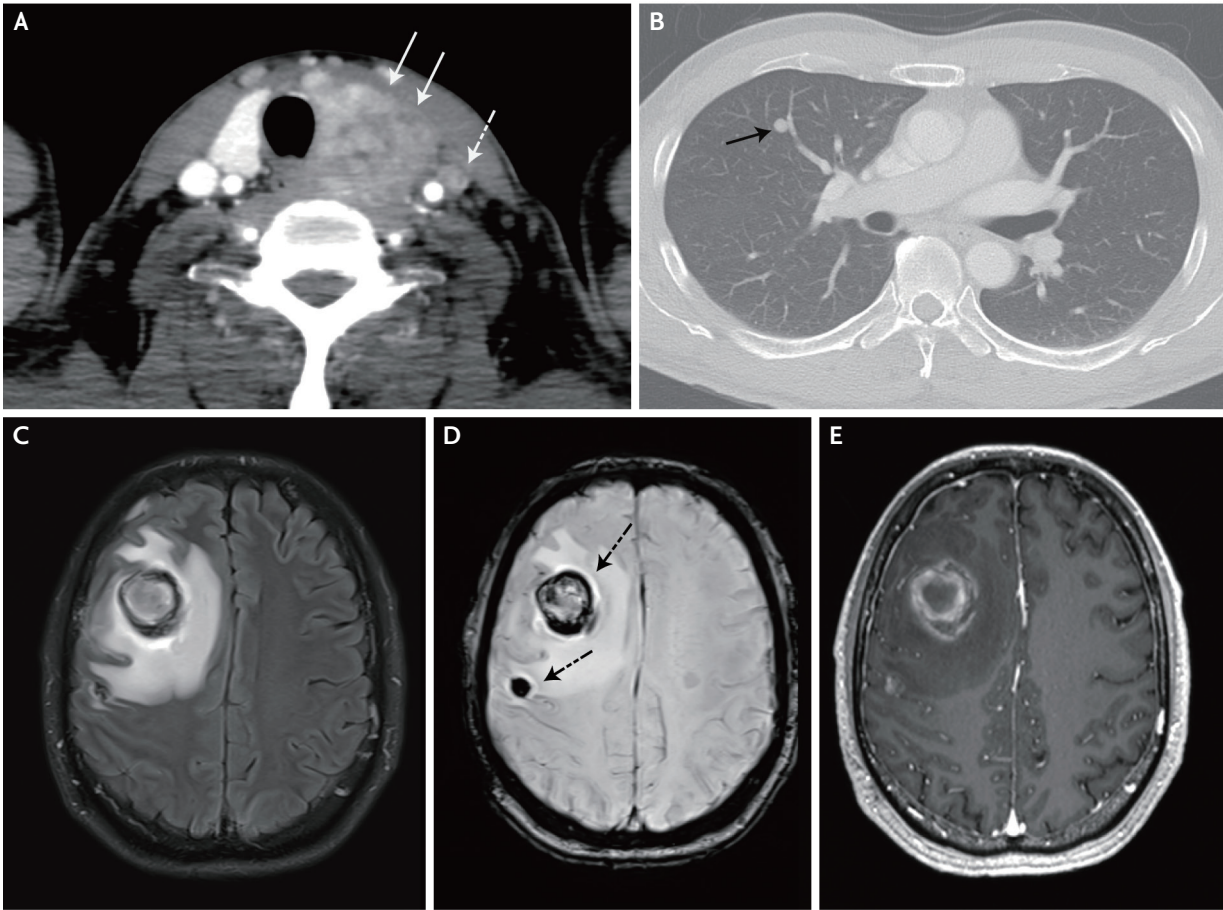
Representative case of a 54-year-old male patient with anaplastic thyroid cancer and brain metastasis. (A) Neck computed tomography (CT) demonstrates a large mass replacing the left thyroid gland with extrathyroidal extension (white arrow) and a nodal metastasis (white dotted arrow) in the left level III. (B) Chest CT reveals a lung metastasis (black arrow) in the right middle lobe. (C) Fluid attenuated inversion recovery displays multiple brain metastases with peri-regional edema in the right frontal lobe. Brain metastases show hemorrhage (black dotted arrow) on susceptibility-weighted image (D) and enhancement on contrast-enhanced T1-weighted image (E).
